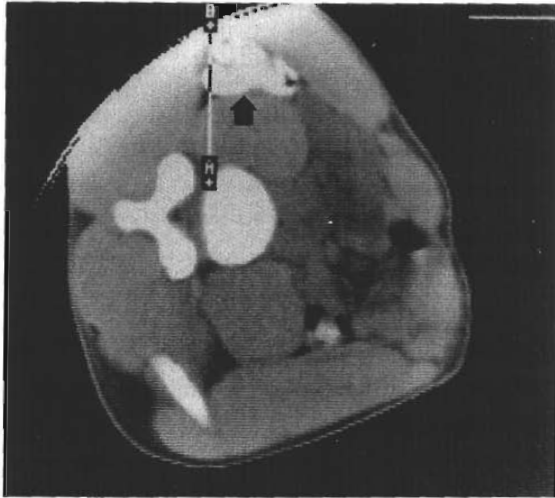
This CT scan, performed in an identical fashion but in a very muscular patient, shows the ascending colon (*arrow*) clearly in the projected surgical path. A large psoas muscle lies between the colon and the lateral aspect of the vertebral body.
